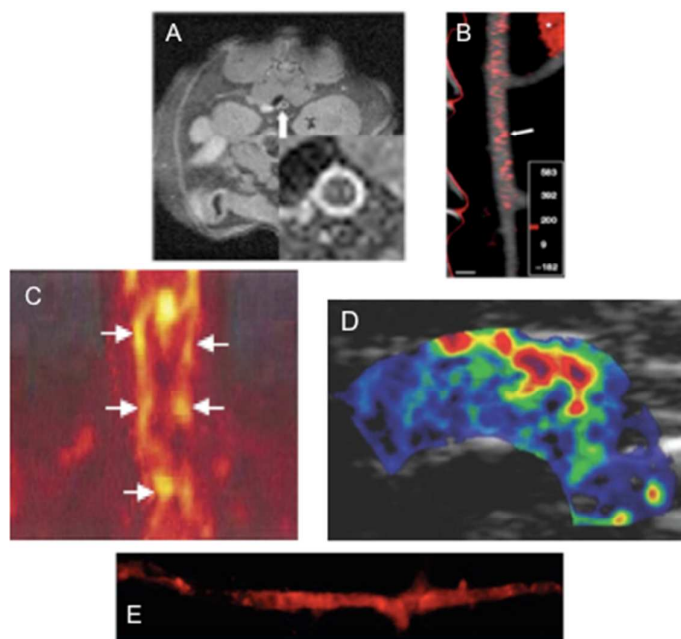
(A) MRI of atherosclerotic lesion with Gd. Arrow points the abdominal aorta, inset denotes magnification [Reproduced from ref 55 with permission]. (B) CT of atherosclerotic plaques in aorta with I. The white arrows point to red spots where atherosclerotic plaques were detected [Reproduced from ref 105 with permission]. (C) PET imaging with ^{18}F of carotid and aortic arch arteries [Reproduced from ref 142 with permission]. (D) Ultrasound targeted microbubbles in aortic arch for early stages of intimal xanthoma [Reproduced from ref 178 with permission]. (E) Fluorescence image of aorta injected with Qdots. The red color is due to the presence of plaques [Reproduced from ref 13 with permission].
